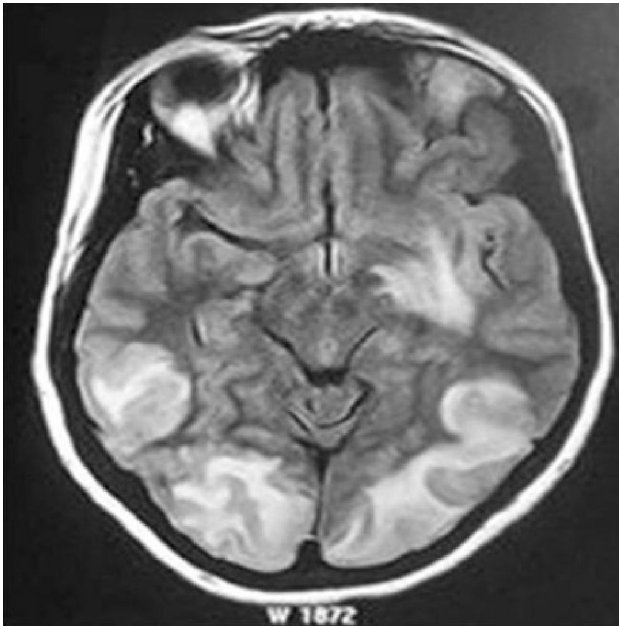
T1weighted MR images showing hypointense PRES lesions in temporo-occipital regions .
